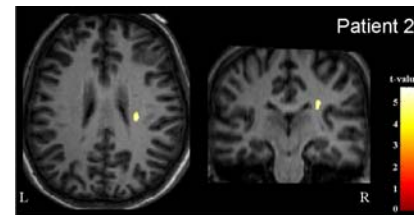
Area showing significant decrease of FA in the white matter of patient 2 in comparison to the collection of normals ($p_u < 0.001$) superimposed on the normalized T1-weighted anatomical image of patient 2 (Talairach-coordinates: 28, -24, 24). L = left; R = right.
